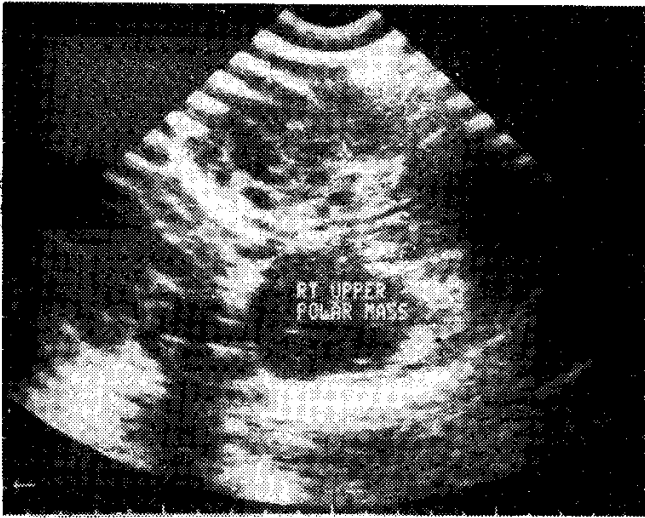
Longitudinal upper abdominal sonogram showing a hyperechoic mass above right kidney representing an acute adrenal hemorrhage.
